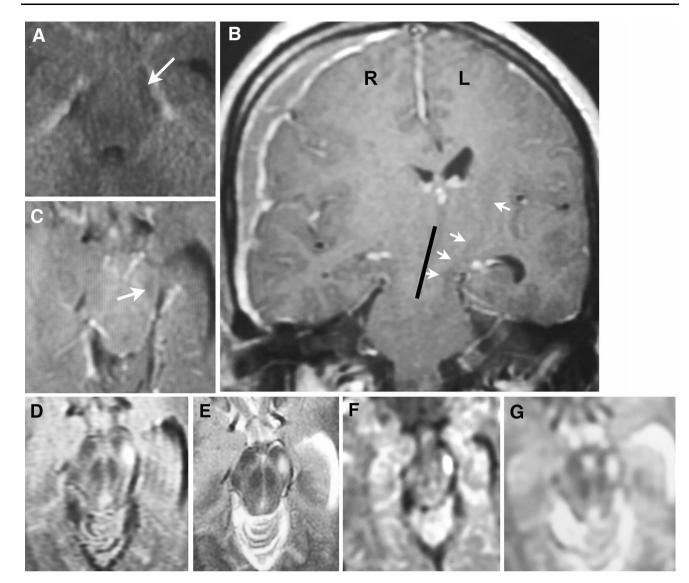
Thirty-six-year-old male was beaten up, found moderately lethargic (stuporous), only intermittently followed commands, and Glasgow Coma Score was 10. A right hemiparesis was present. a CT scan of the brain disclosed a large right-sided subdural hematoma with midline shift, a right basifrontal hemorrhagic contusion, and smaller bitemporal contusions. The basal cisterns showed an abundance of subarachnoid hemorrhage and a possible area of low density in the left midbrain cerebral peduncle (*arrow*). Due to the prominent subarachnoid hemorrhage as well as weakness ipsilateral to the subdural, MRI/MRA of the brain was obtained and no vascular lesions were detected. b MRA—*coronal view* shows the large subdural, and right to left shift with angulation of the diencephalic-midbrain region (*solid line*). An altered signal intensity (*white*
